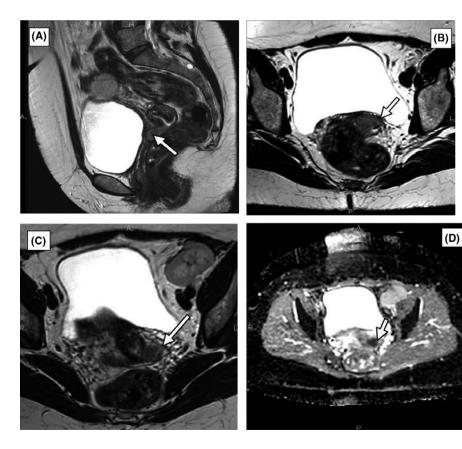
Tumor visualization with sagittal (A) and axial (B) T2-weighted MR images, revealing a cervical carcinoma with vaginal infiltration (A, B, arrows). Visualization by axial T2-weighted view (C, arrow) and DWI image (D, arrow) reveals left parametrial invasion—loss of the hyperintense cervical rim on the left lateral aspects of the cervix, with the irregular interface between the tumor and the parametrium. No pelvic adenopathy was noted
